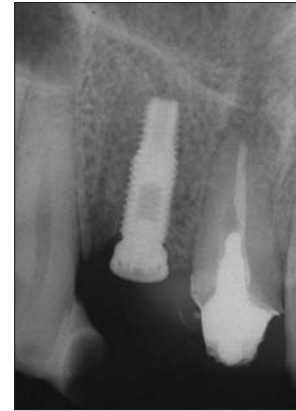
Radiographic assessment 6 months after implant placement.
